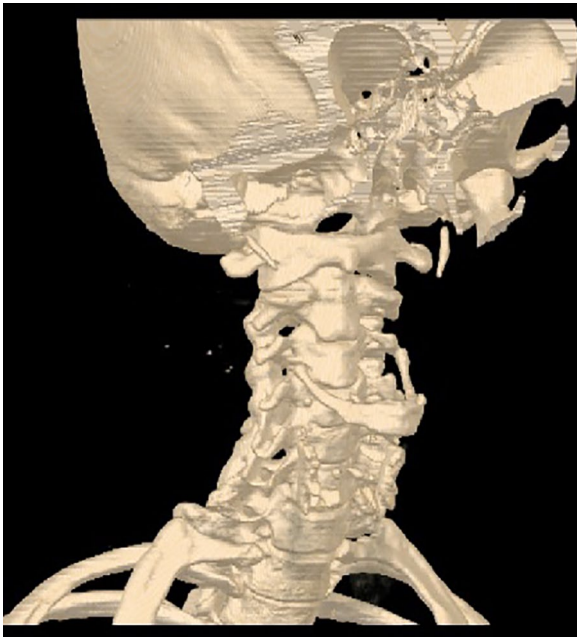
Three-dimensional reconstruction of computed tomography images. A coronal view showed the elongated left styloid process.
